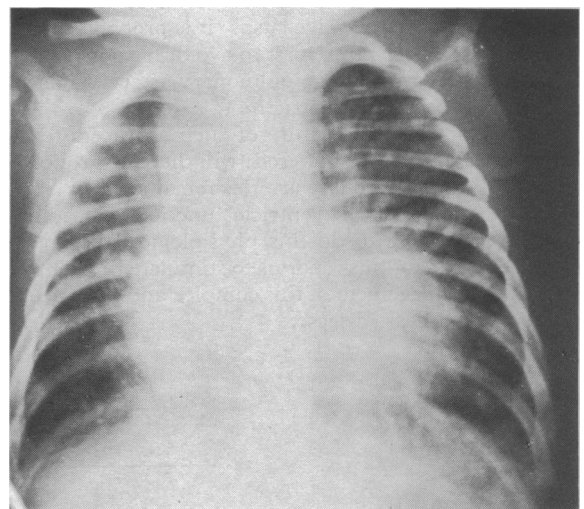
Case 1. Preoperative chest radiograph showing cardiomegaly and plethoric lung fields.
